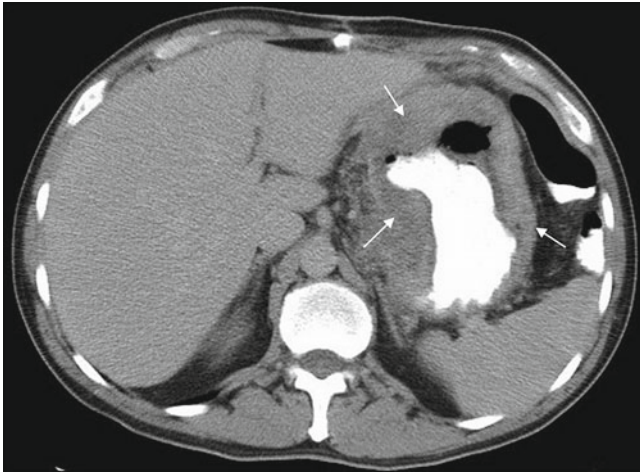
An 80-year-old man is evaluated for a 3-month history of progressive, dull, constant, non-radiating epigastric pain. The patient has had weight loss with early satiety and nausea. Axial oral contrast enhanced CT image at the level of the gastric fundus shows a thick infiltrating mass (*white arrows*) which surrounds the irregular contrast filled lumen. Diagnosis: Gastric cancer
